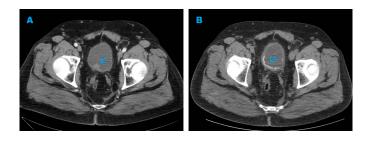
Axial view of CT scan showing a bladder mass (blue arrow in Figure 1A) on the posterior wall (A) and calcification (blue arrow in Figure 1B) on the posterior bladder wall at the resection site (B).
